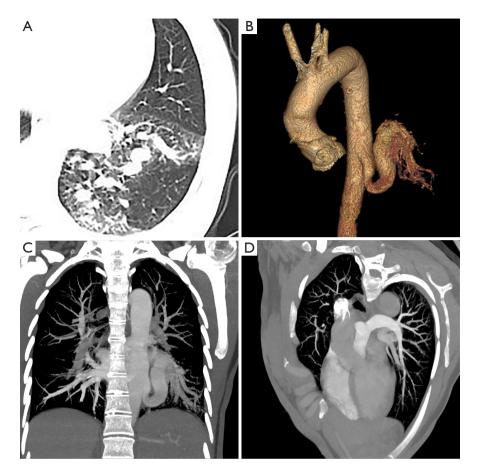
Preoperative images. (A) Chest CT demonstrates a significant increase in the blood vessel volume and tortuosity of the left lower lung lobe. (B,C) Aortic artery CTA demonstrating an enlarged tortuous artery originating from the descending thoracic aorta perfusing into the left lower lung lobe. (D) Pulmonary artery CTA showing a normal left pulmonary artery with a relatively sparse lower branch. CT, computed tomography; CTA, computed tomography angiogram.
